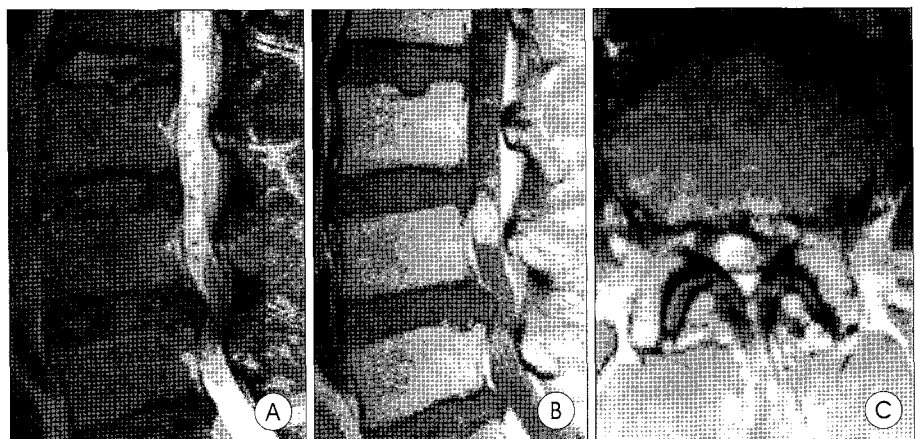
On magnetic resonance images, sagittal T2 weighted sequence shows multiple vascular signal voids seemed to be abnormally dilated serpiginous vessels (A). On enhanced sagittal T1 weighted sequence the tumor appears to be homogeneous intradural enhancing mass with Gadolinium-DPTA-dimeglumine contrast at the L4 level (B). Axial T1 weighted sequence with contrast shows enhancing mass occupying most of the spinal canal (C).
